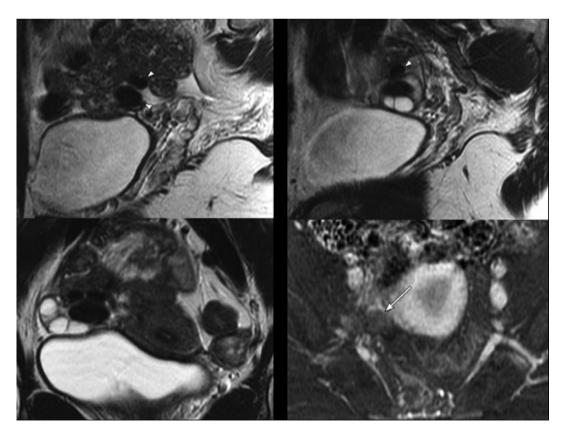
Magnetic resonance imaging (MRI) demonstrates well-circumscribed T1-T2 hypointense nodular lesions (arrowhead) with heterogeneous enhancement on post-contrast sequences (arrow). Bilateral ovarian cysts were also noted
